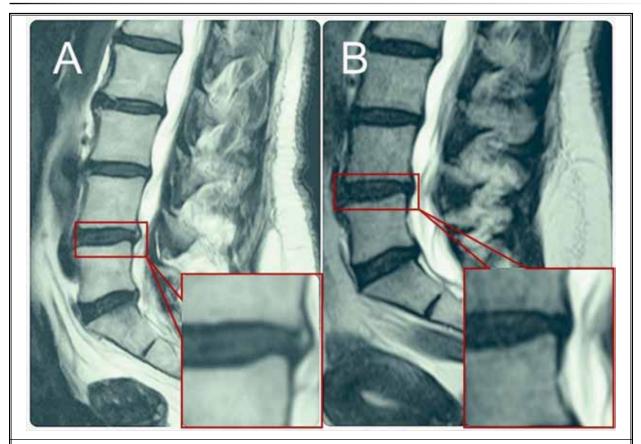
An exemplary patient treated with intradiscal injection of 5 million allogeneic progenitor cells in 1% hyaluronic acid for painful intermediated degenerative disc disease at L4/5. The preoperative sagittal T2-weighted MRI scan (A) showed Pfirrmann grade III disc degeneration with an annular tear (cutout A). The one-year follow-up MRI scan (B) suggests that the intradiscal allogeneic progenitor cells injection seems to have promoted healing of the annular tear (cutout B).
